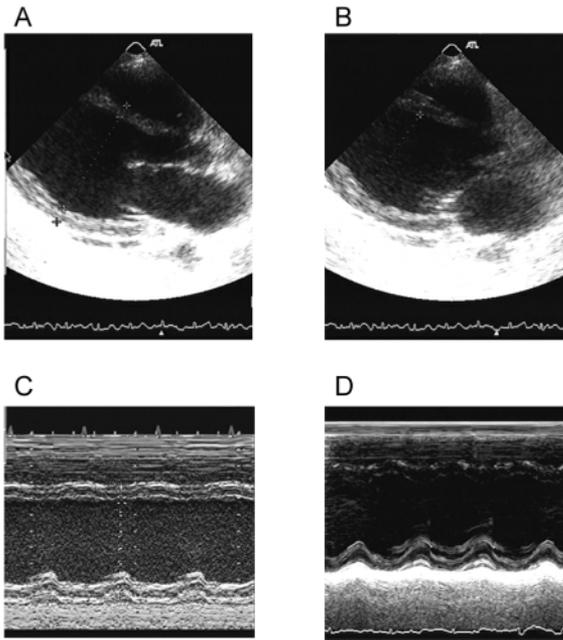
A and B, Parasternal long-axis B-mode view of the echocardiogram in end diastole (A) and end systole (B) on patient admission. The left ventricle was markedly dilated and severely hypokinetic. C and D, M-mode view of the left ventricle at the level of the tendinous cords on admission (C) and 9 months after the administration of tocilizumab (D).
